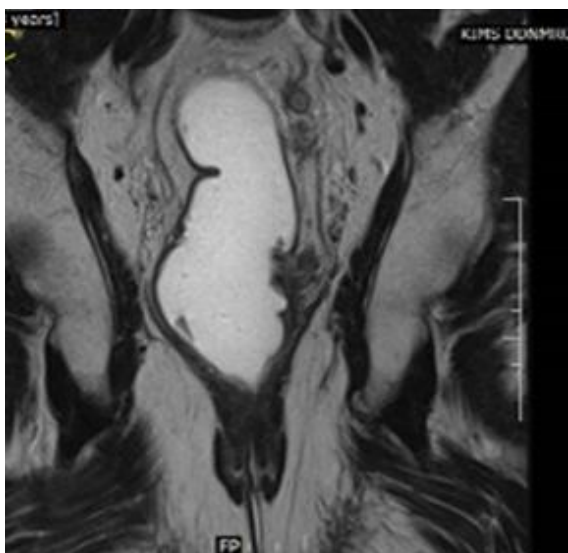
MRI T2W coronal images showing a semi-annular morphology
